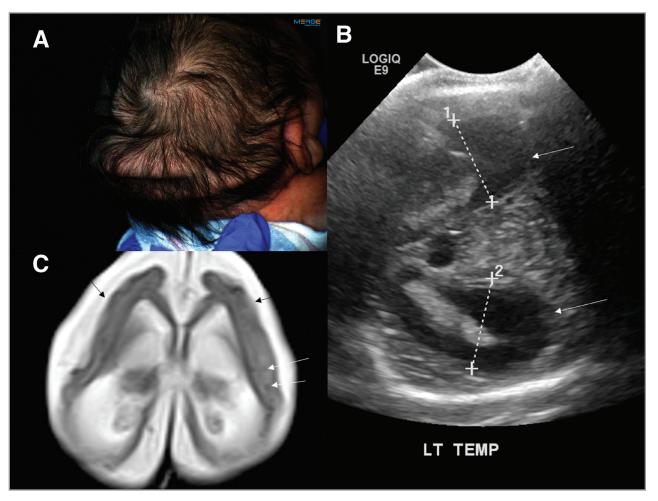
Clinical features of full-term infant with congenital Zika syndrome. (A) Posterior view of excessive scalp folds. (B) Cranial ultrasound using a mastoid window demonstrating moderate ventriculomegaly (white arrows). (C) Axial T2-weighted magnetic resonance imaging of the brain demonstrating marked prominence of the extra axial spaces and ventriculomegaly consistent with severe atrophy of the brain and a simplified gyral pattern (short black arrows). Punctate hypointensities consistent with calcifications are also seen in the periventricular white matter (long white arrows).
